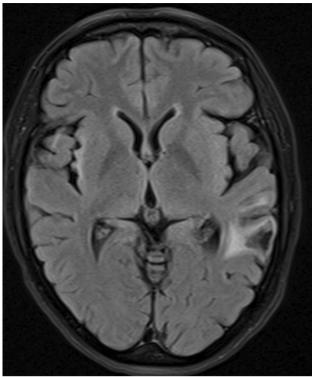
MRI axial FLAIR sequence showed clear improvement of FLAIR hyperintensities but with appearance of atrophy next to lesions in case no. 1, 4 months after COVID-19 vaccination
